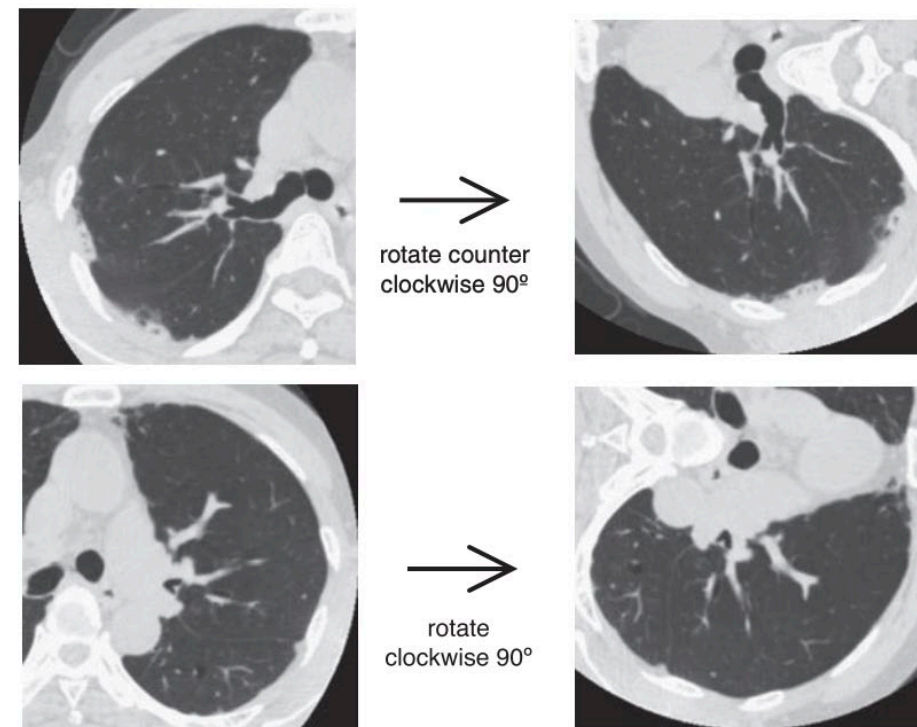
To rotate CT images
